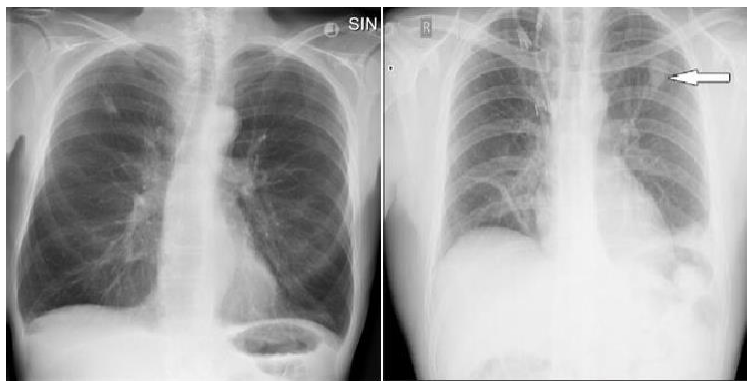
a Chest X-ray showing infiltrate in the right lung.
